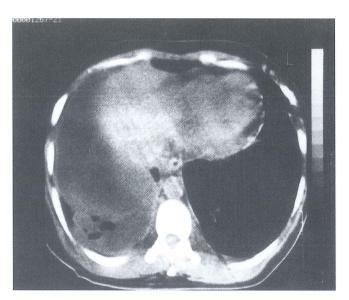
CT scan: right pleural effusions.
